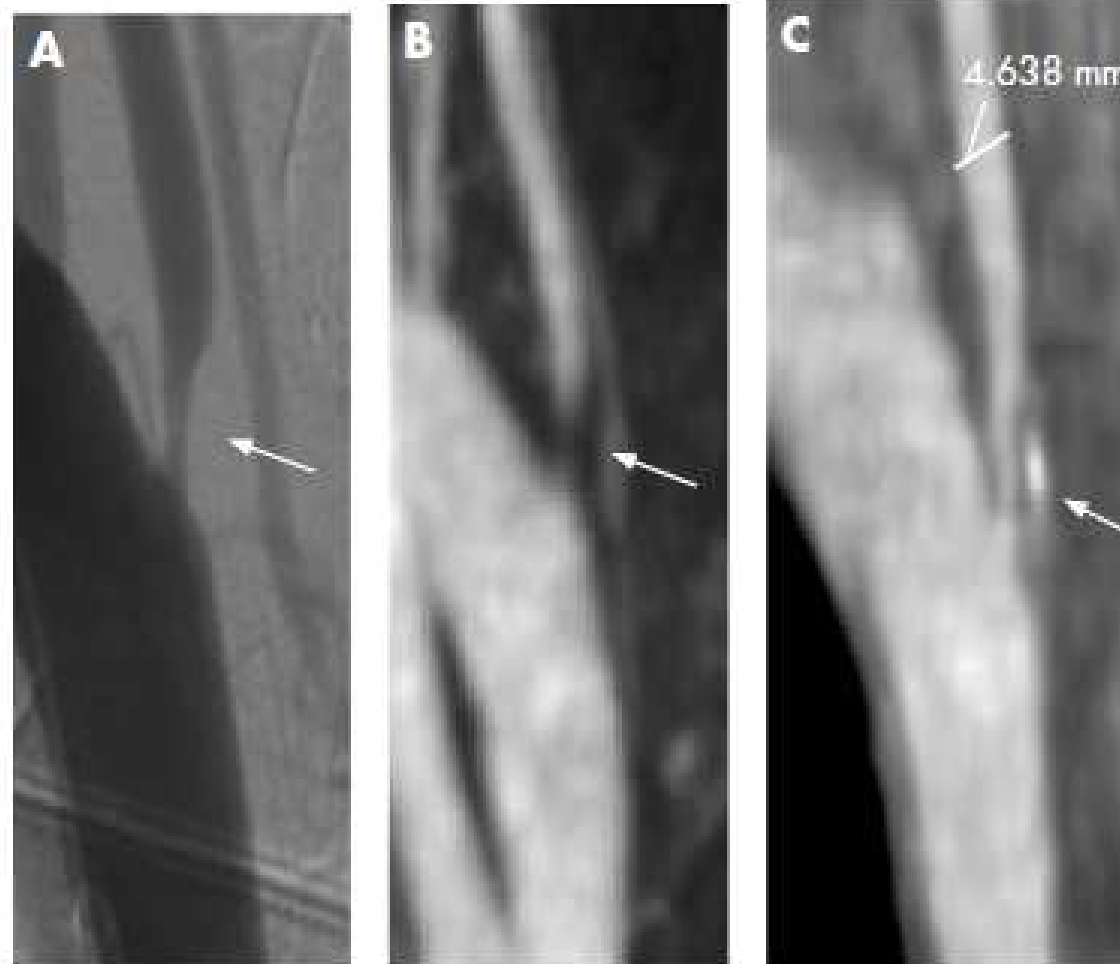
Intra-arterial angiography (IAA), extracranial contrast enhanced magnetic resonance angiography (CE-MRA) and computed tomographic angiography (CTA), demonstrating right vertebral artery stenosis in a 64-year-old patient who presented with a posterior circulation stroke. (A) IAA with right subclavian artery injection; (B) extracranial CE-MRA maximum intensity projection image; (C) extracranial CTA sagittal reformatted image.
